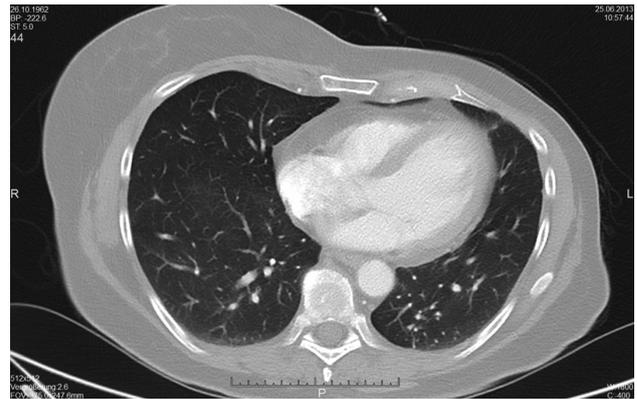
Thoracic CT-scan, acquired in pulmonary window, after nine cycles of treosulfan in June 2013.
